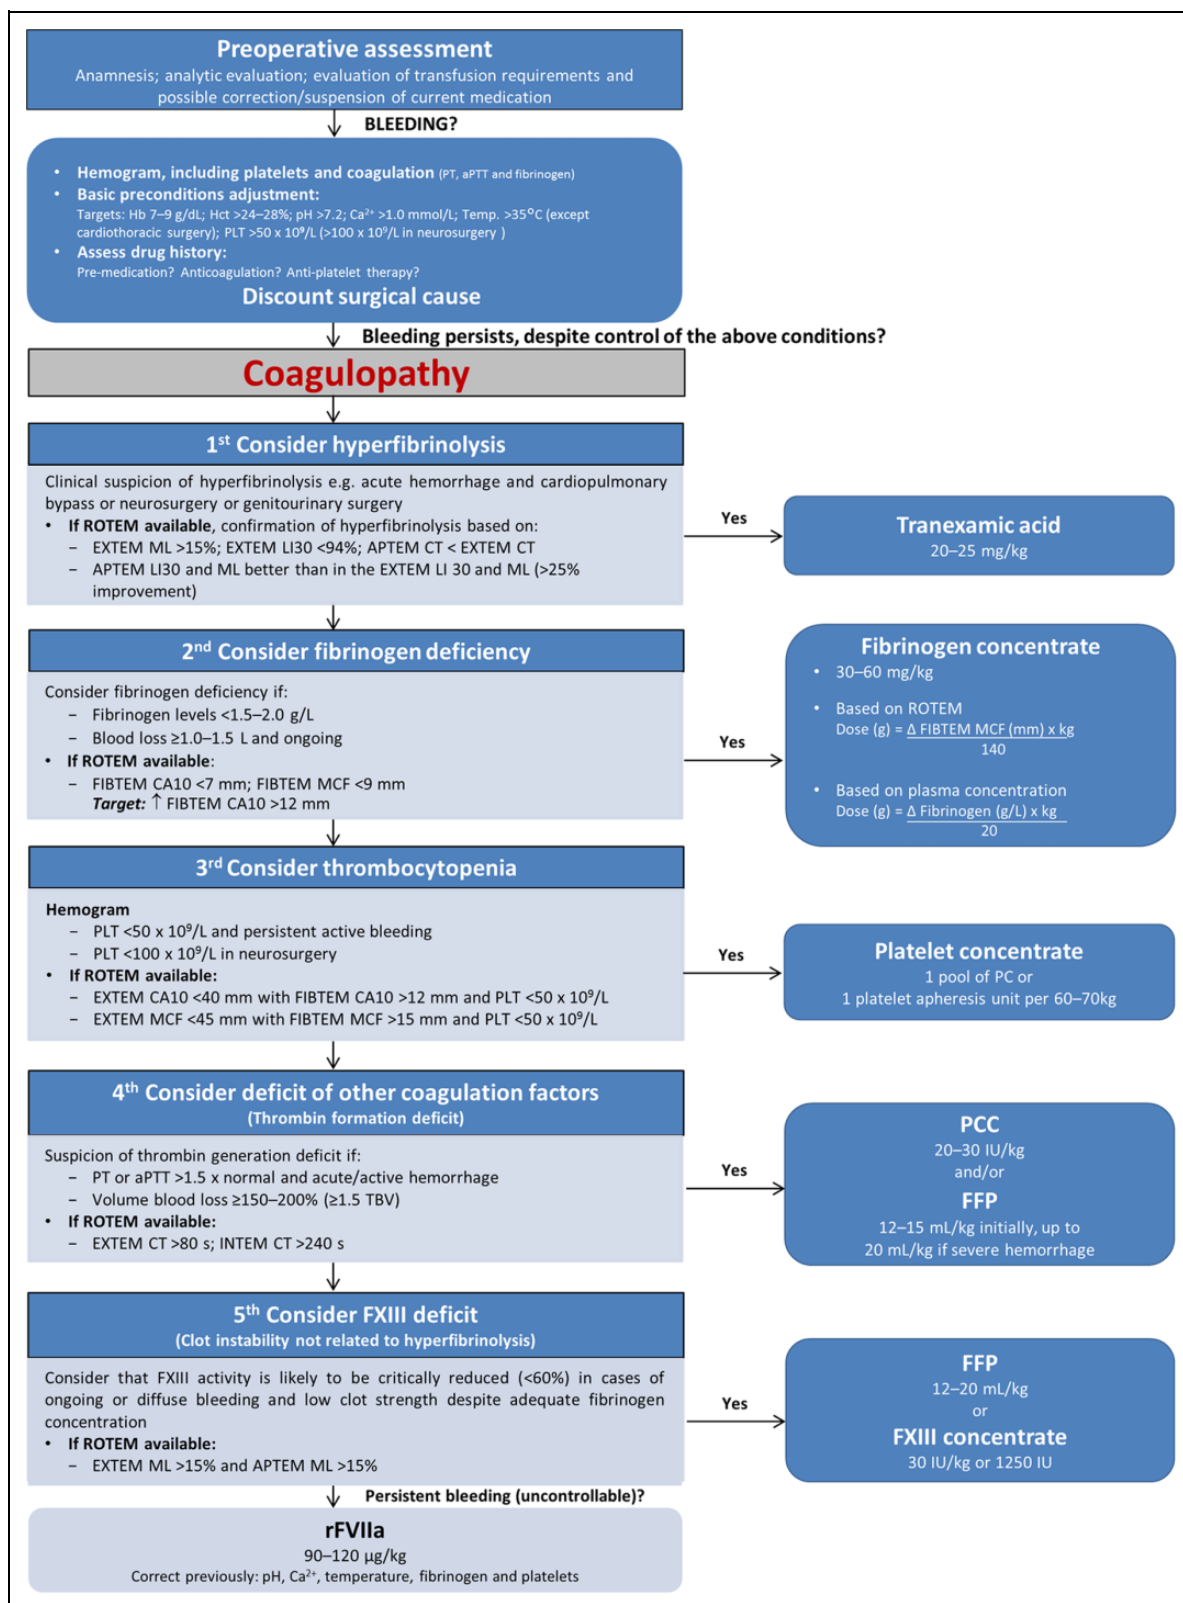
Proposed algorithm for the management of coagulopathic bleeding in surgical settings. aPTT indicates activated partial thromboplastin time; CA10, clot amplitude after 10 minutes; CFT, clot formation time; CT, clotting time; FFP, fresh frozen plasma; Hb, hemoglobin; Hct, hematocrit; LI30, lysis index after 30 minutes; MCF, maximum clot firmness; ML, maximum lysis; PC, platelet concentrate; PCC, prothrombin complex concentrate; PLT, platelet count; PT, prothrombin time; TBV, total blood volume.
